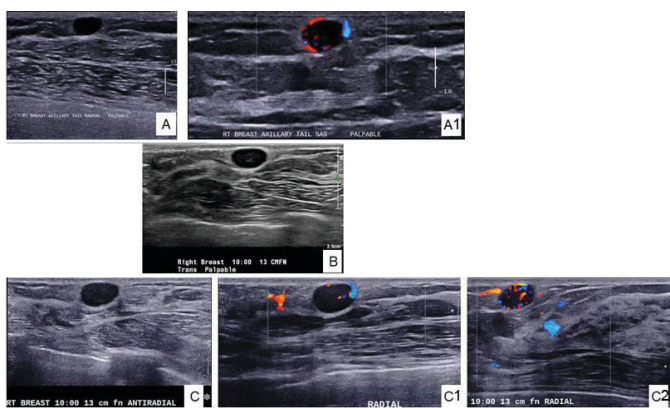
Sonogram. (A) Obtained in 2017, (B) Obtained in 2020, (C) Obtained in 2023.
